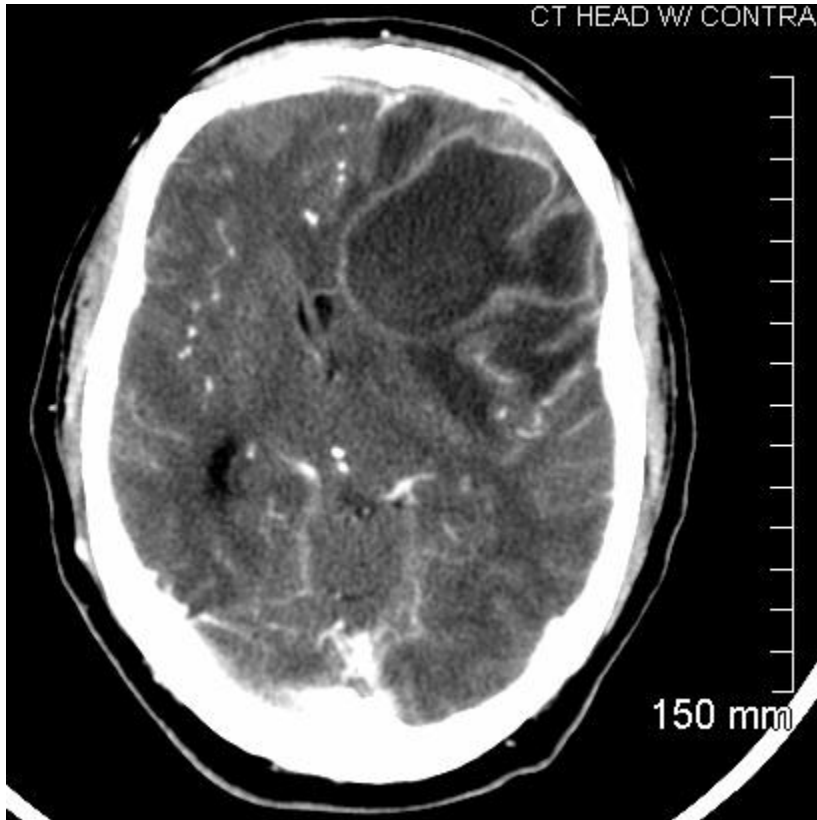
CT image shows a contrast study demonstrating a 4.4 x 6.3 cm ring-enhancing lesion in the left frontal lobe with hypodense center suggesting either a necrotic mass or a brain abscess.
